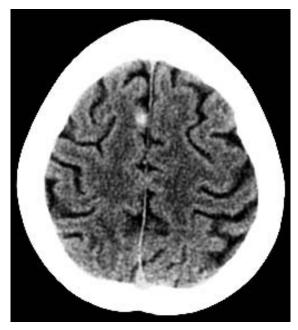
Axial non-enhanced brain CT image showing focal rounded hyperdensities in the medial aspect of the right frontal cortex consistent with cortical bleeding
